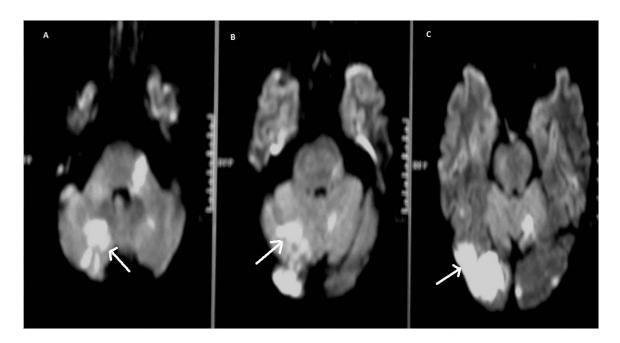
Fifty-five-year-old male presented with recurrent posterior circulation transient ischemic attacks. MR DWI revealed acute infarcts in the bilateral vertebrobasilar territory as shown by arrows in (a), (B), and (C).
